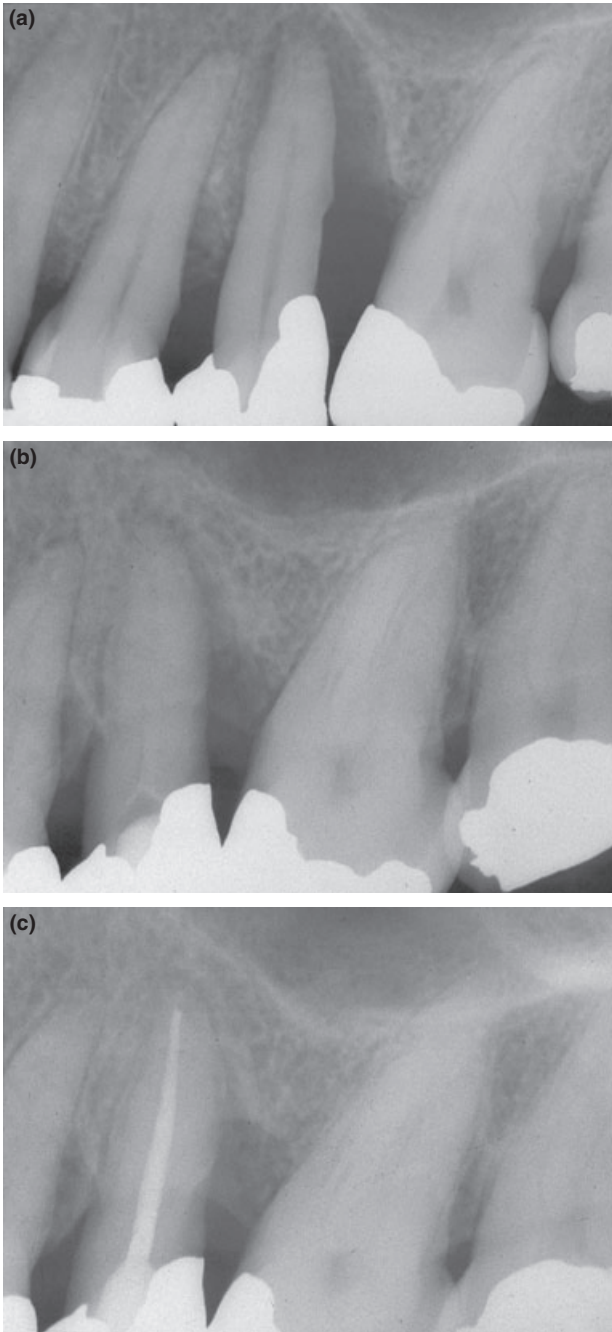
Management of an upper left second premolar tooth with concurrent endodontic and periodontal diseases that communicated with each other. The tooth had a pulpless, infected root canal system with chronic apical periodontitis as a result of breakdown of the coronal restoration. It also had a deep periodontal pocket on the distal aspect. The patient also had generalized periodontal disease. (Reproduced with permission and courtesy of the *Journal of the New Zealand Society of Periodontology*.) (a) The pre-operative radiograph shows a very deep metallic restoration and a periapical radiolucency communicating with the distal periodontal pocket. There has been marked bone loss on the distal aspect. The radiograph also suggests that there is no contact point between this tooth and the first molar tooth, and hence food packing may have been a contributory factor to both the periodontal and endodontic problems. (b) Periapical radiograph taken two months after treatment was commenced. The root canal system was cleaned and medicated, followed by initial root planing and oral hygiene instruction. At this stage, some periapical bone repair is evident but there is still some distal periodontal pocketing so further periodontal treatment and re-dressing of the canal were indicated. (c) Periapical radiograph taken at the time of placing the root canal filling which was done six months after the initiation of endodontic treatment. Intracanal medications were utilized while the periodontal treatment was provided. The periodontal treatment initially involved root planing and oral hygiene instruction. After three months, periodontal access surgery was performed in order to facilitate further root planing. At this stage, periapical bone repair is evident as well as bone repair within the distal periodontal pocket.
